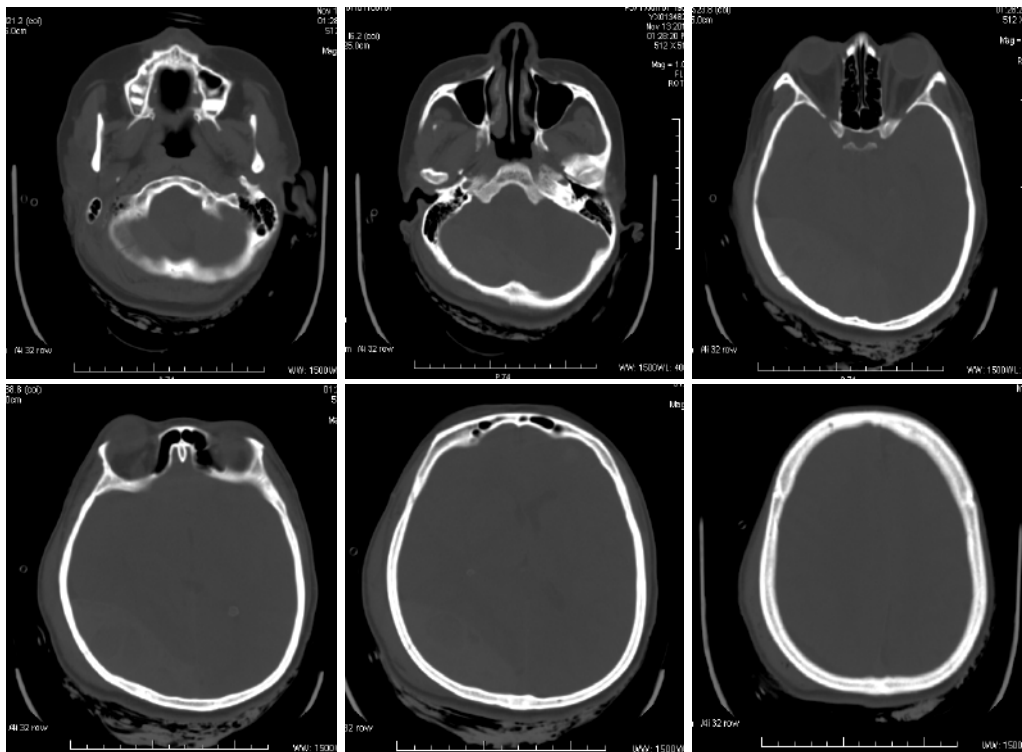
CT bone window of the head demonstrates a linear fracture of the right occipital region extending from the foramen magnum to the lateral ventricle
